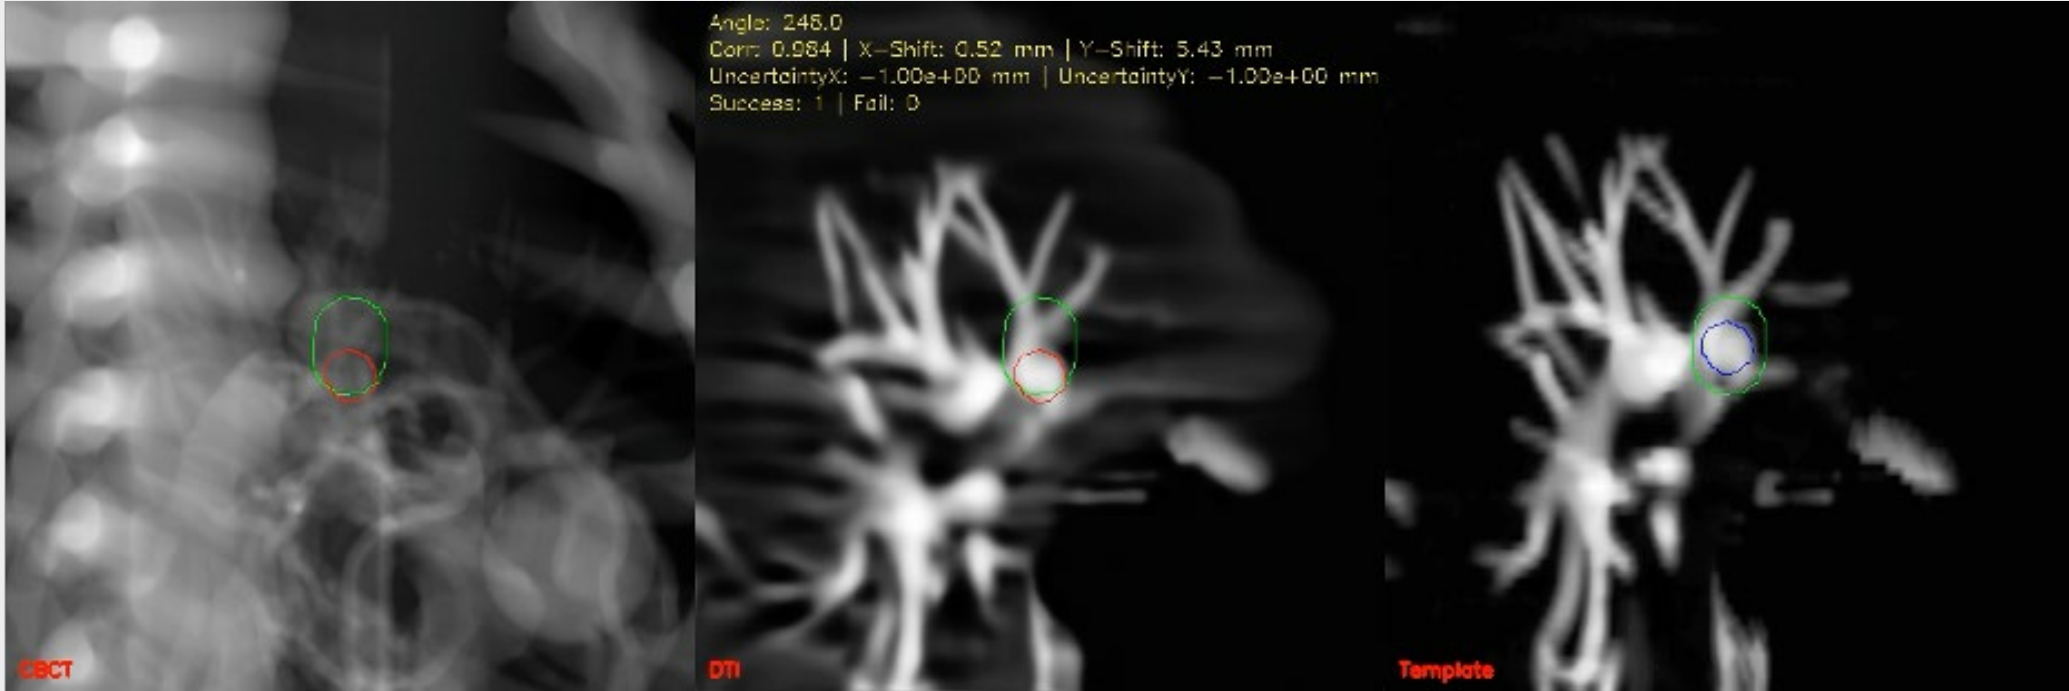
From left to right: CBCT, real-time generated DTI, and the template generated from planning CT. Green circle is PTV and red circle is GTV
